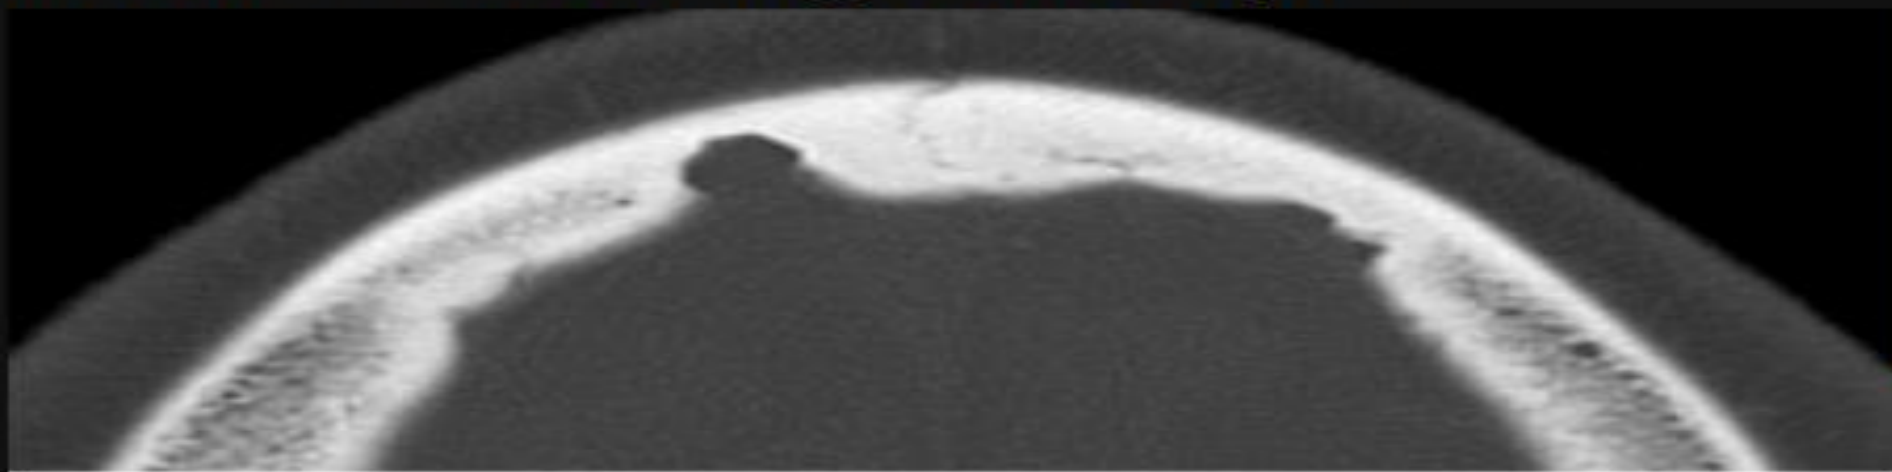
of 11. CT Anatomy of skull, axial reconstruction, bone window.
